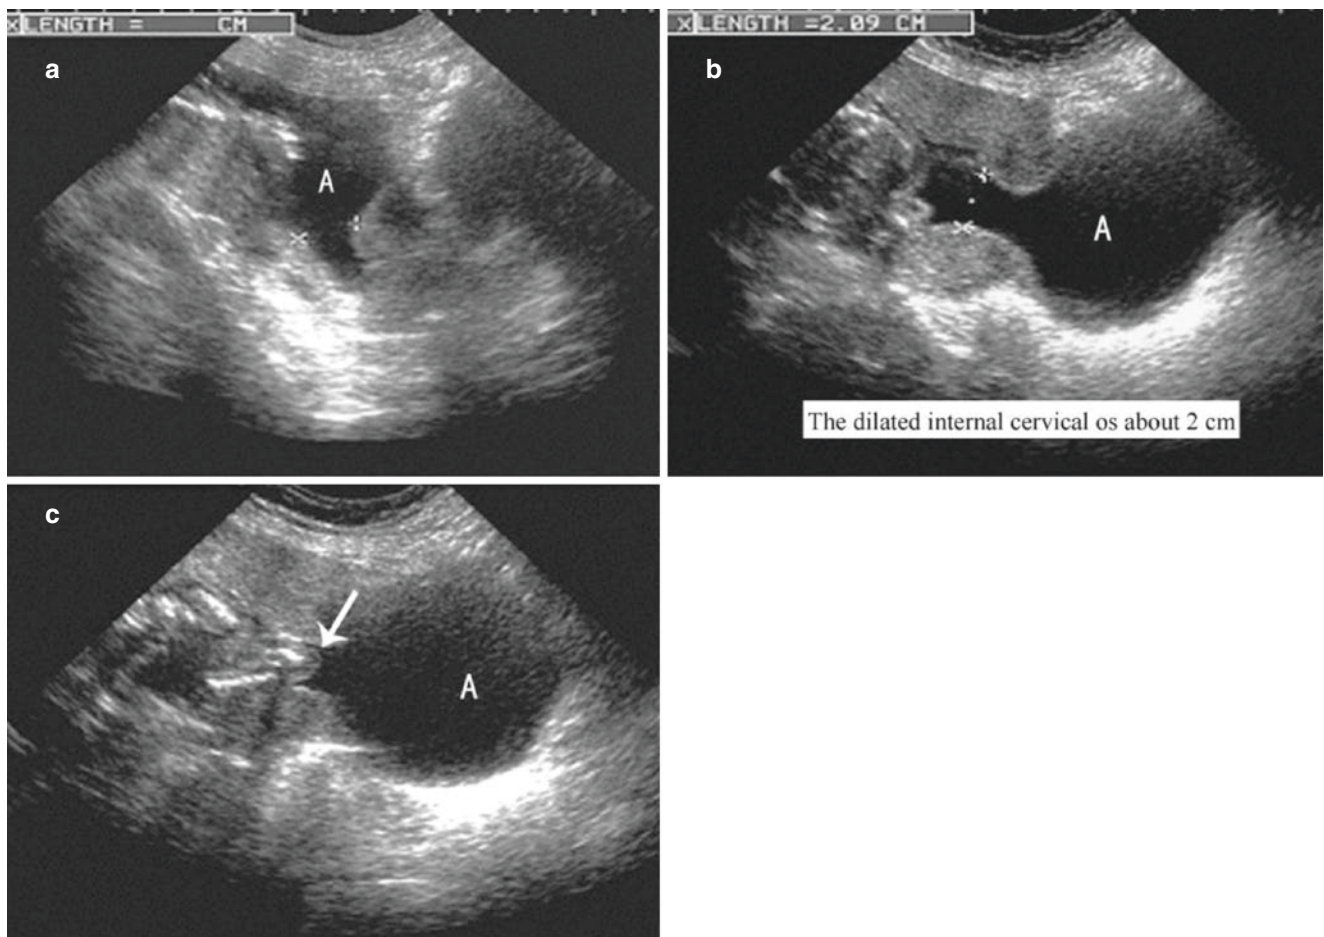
Cervix relaxation (II). (a). The patient had 5 pregnancies with spontaneous abortion. At 26 weeks of the sixth pregnancy, the sonogram shows the shortened cervix and the dilated internal cervical
